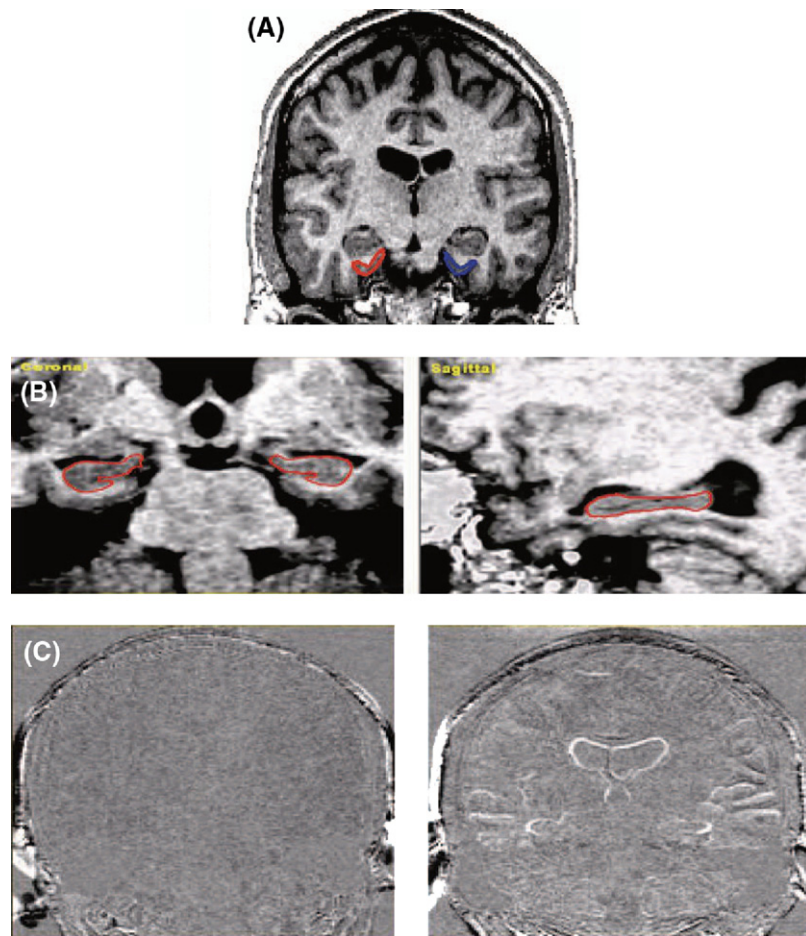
Figure e-1. Magnetic resonance images from the training manual. (A) Entorhinal cortex (ERC) on coronal slice: representative T1-weighted magnetic resonance imaging (MRI) scan showing a coronal section through the ERC. The boundaries of this small brain structure, derived manually using anatomical landmarks, are highlighted in red (right ERC) and blue (left ERC). (B) Hippocampus on coronal and sagittal slices: representative T1-weighted MRI showing a coronal and sagittal section through the mesial temporal lobe including the hippocampus. The boundaries of the hippocampus, derived automatically by warping an atlas brain onto this individual brain image, are highlighted in red. (C) Pairs of whole brain scans with boundary shifts highlighted: results of boundary shift integral (BSI) analyses of 2 pairs of images acquired about 1 year apart. The BSI results on the left, lacking any observable feature, suggest that there has been no major volume change of the brain. The BSI results on the right, highlighting boundary shifts, indicate enlargements of ventricles and sulcal spaces, consistent with brain volume loss.
